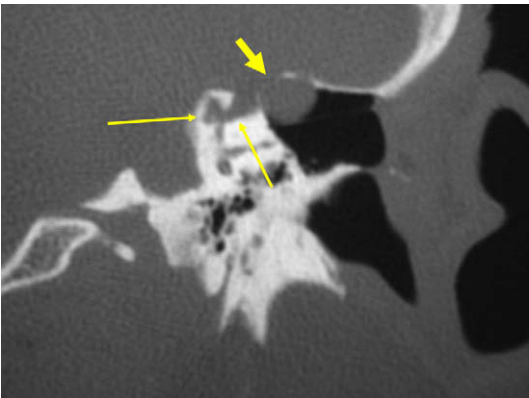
Coronal CT image in patient following mastoid surgery for cholesteatoma. The patient experienced hearing loss and dizziness. Note the bone erosion involving the posterior semicircular canal (*thin arrows*). There is a contiguous round mass along the caudal margin of the dehiscent tegmen (*thick arrow*). The appearance of the round mass is consistent with cholesteatoma, cholesterol granuloma, meningocele, or encephalocele.
